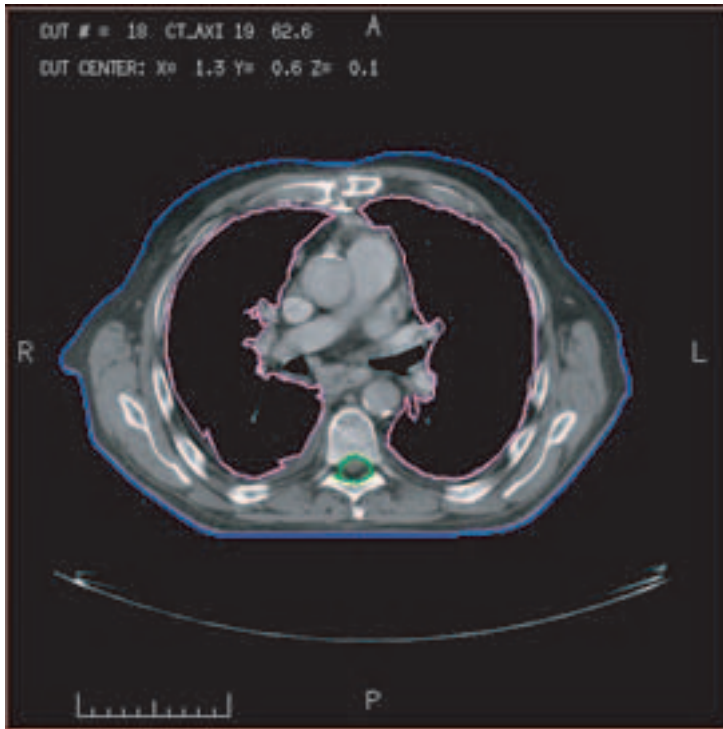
CT scan with automatically segmented contours. Contours (the lungs and spinal cord are shown) can be generated by automatically extracting contours for objects that have different densities than the surrounding tissues (e.g. lung or bone).
